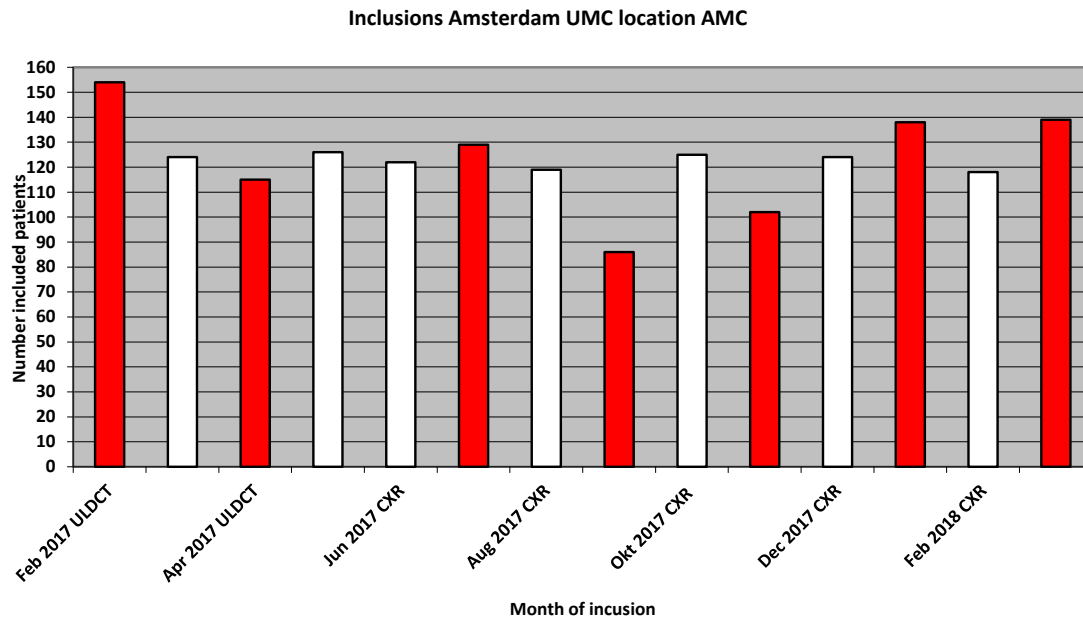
Inclusions per month and per inclusion site. Red bars: ultra-low-dose chest computed tomography (ULDCT), White bars: chest X-ray (CXR)
